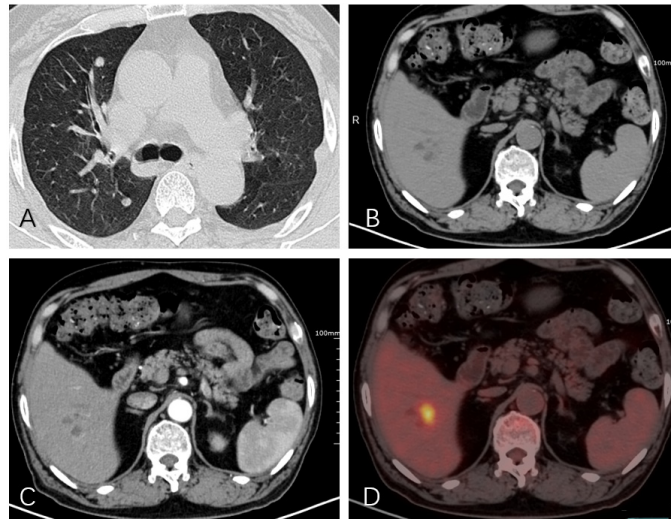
(A) Axial lung window showing bilateral lung metastases. (B) Axial CT image showing cystic and solid mass in the liver (C) Marked enhancement of the solid part in the arterial phase (D) Active metabolism of the intrahepatic mass.
